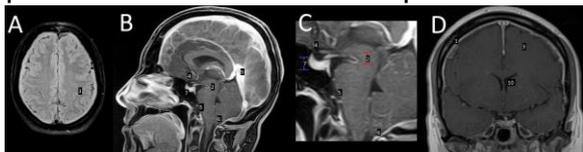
Axial FLAIR (A), sagittal (B and C) and coronal (D) post contrast T1-weighted sequence performed after 6 days of the lumboperitoneal shunt depicting [1] pachymeningeal enhancement, brain "sagging" ([2] reduction of the mamillopontine distance, [3] obliteration of the convexity sulci, [4] obliteration of the periquiasmatic and [5] pre-pontine cisterns, [6] inferiorization of the cerebellar tonsils, [7] pituitary enlargement), [8] bilateral subdural hygroma, [9] venous sinus engorgement and [10] reduced ventricular size.
